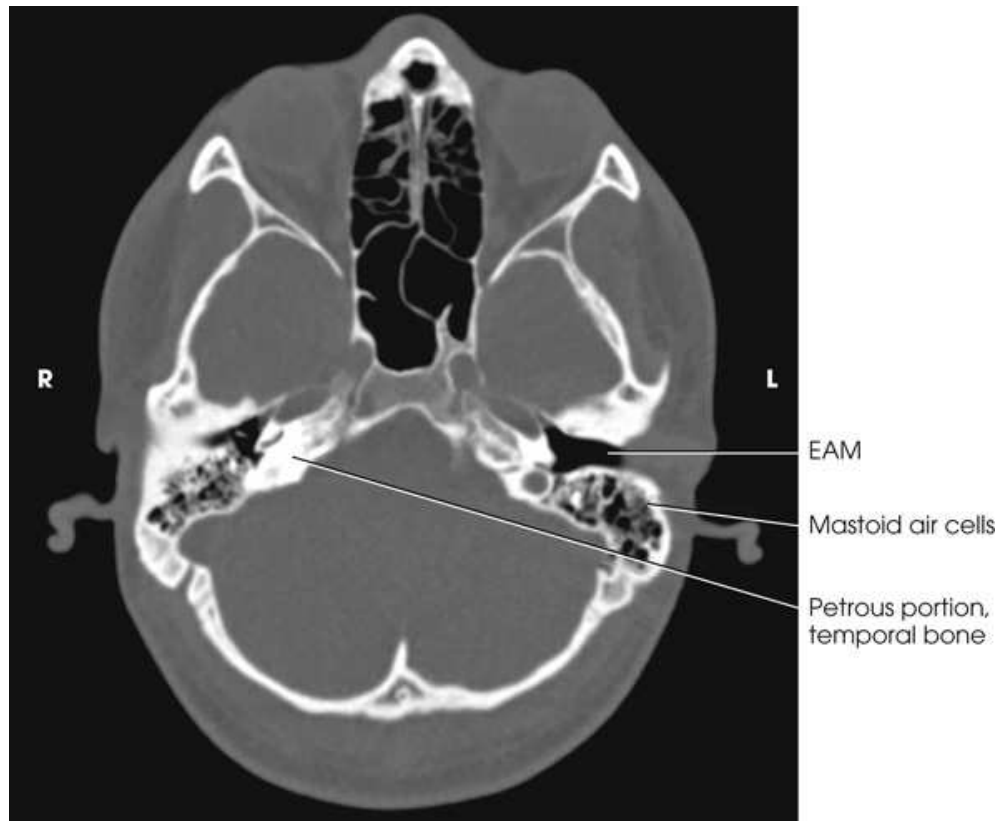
Axial CT scan of petrous portion at level of external auditory meatus (*EAM*). Courtesy Kylee Leath, RT[R][CT], NEA Baptist Memorial Hospital, Jonesboro, AR.
